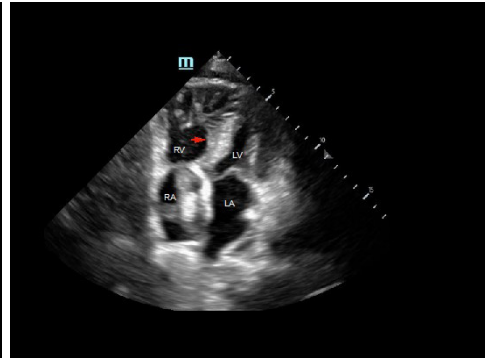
Apical 4 chamber view of the heart showing "bowing of the septum" (red arrow) and RV dilatation.
